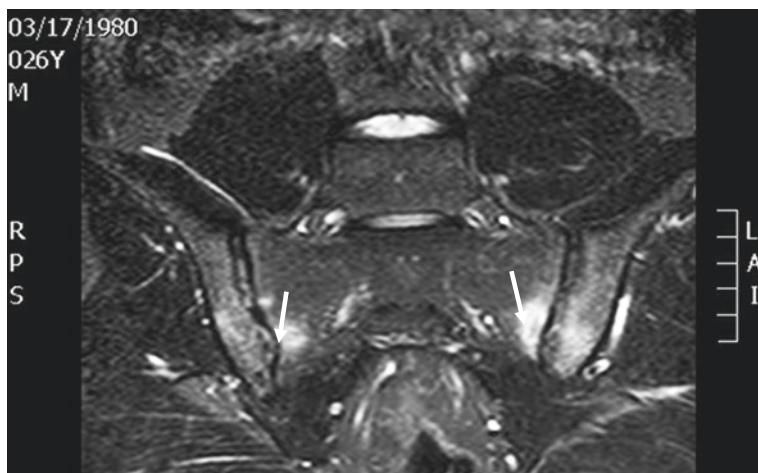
Magnetic resonance imaging of the sacroiliac joints
